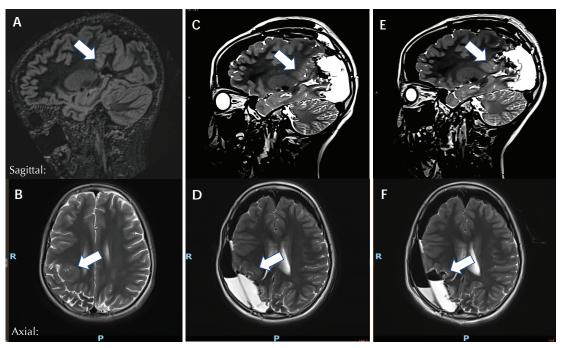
Right parieto-occipital lesionectomy guided by intra-operative MRI. Patient 24 had drug-resistant focal epilepsy from right parieto-occipital polymicrogyria. Pre-operative MRI showed right parieto-occipital lobe polymicrogyria on sagittal image (A; arrow), and corresponding abnormal cortex on axial image (B; arrow). This patient underwent right parieto-occipital lesionectomy at 11 years old. The first intra-operative T2-weighted MRI showed residual abnormal cortex anterior to surgical cavity (C; arrow, D; arrow), further resection of the anterior subcortical margin was performed in the same session (E; arrow, F; arrow). Mild residual abnormal cortex was not shown to be epileptogenic using intra-operative Electrocorticography (ECoG) and decision was made to halt resection at this point so as to preserve motor function. At the six-month follow-up, this patient was seizure free.
